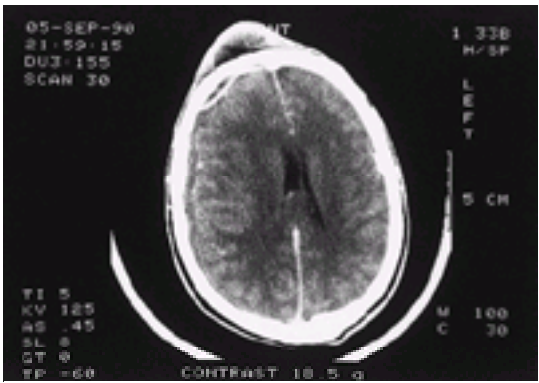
CT scan, with contrast, showing an extradural abscess and Pott's puffy tumour. The infected dura is highlighted by contrast and is stripped away from the skull. In addition there is a subdural abscess showing as a low-density shadow displacing the cerebral hemisphere from the skull. The source of infection was the right frontal sinus.
